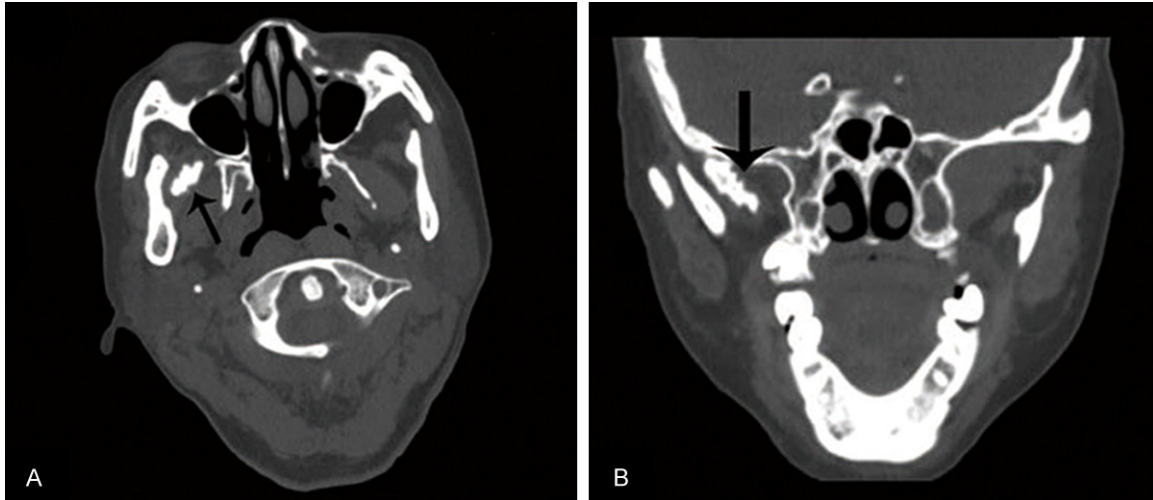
Preoperative CT imaging demonstrated ossification in the lower part of the right temporalis muscle (black arrow). A. Horizontal view. B. Coronal view.
